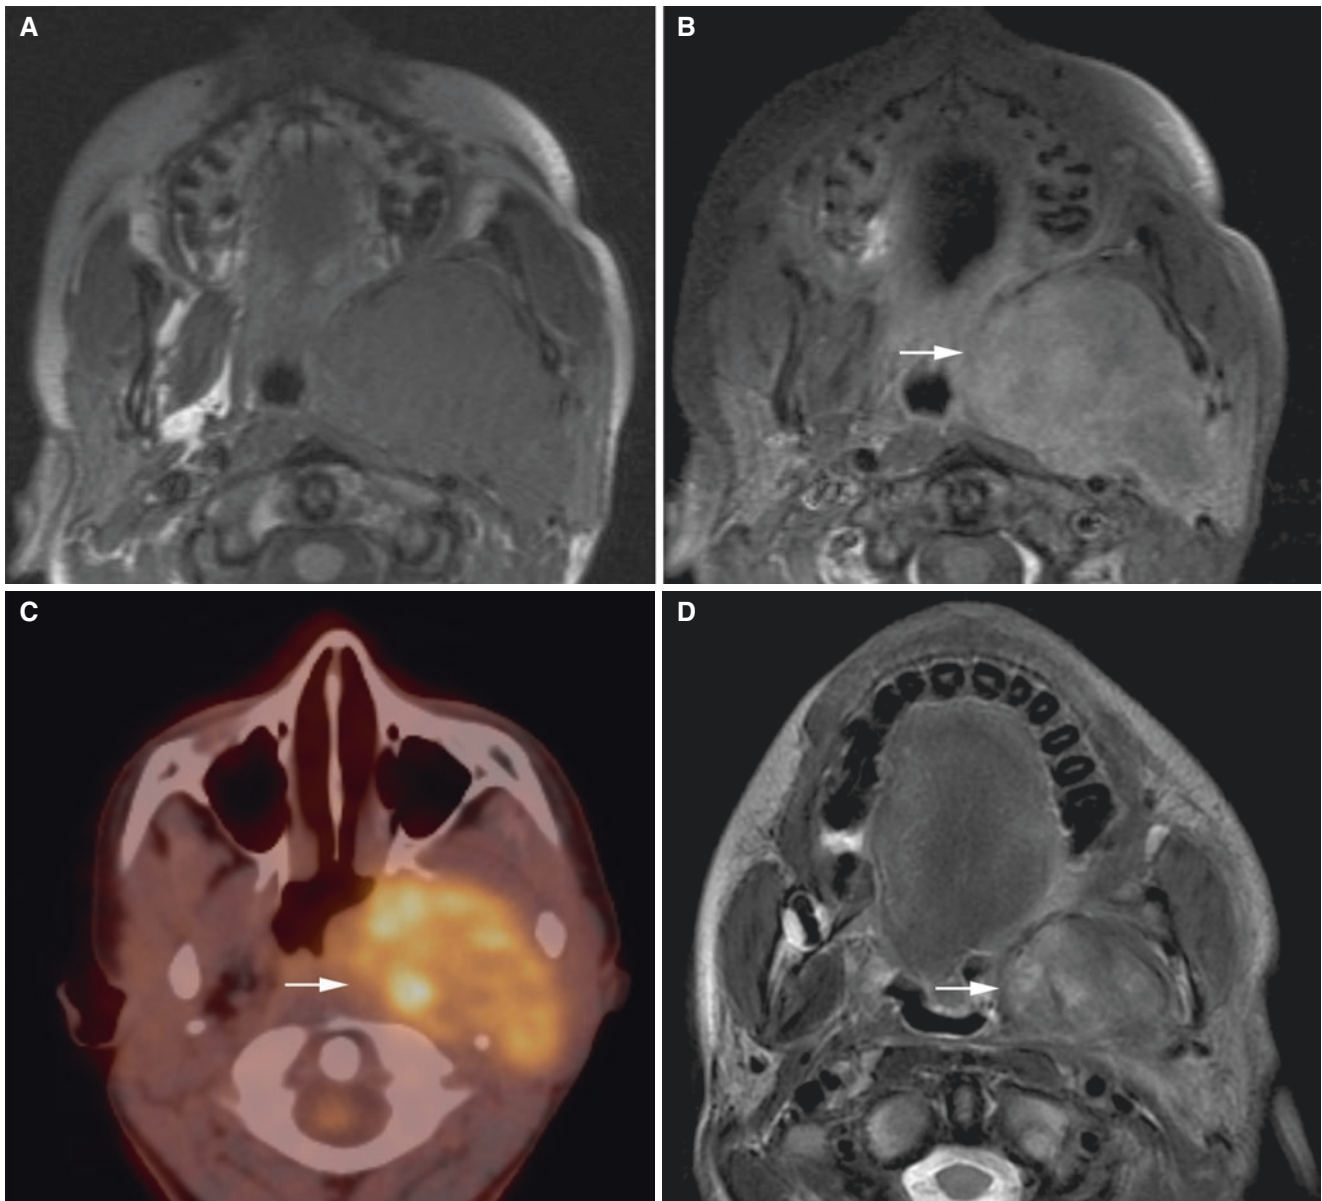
Rhabdomyosarcoma, parapharyngeal; 12-year-old male with trismus and a left-sided neck mass. (A) Axial T1-weighted pre-Gd and (B) axial T1-weighted fat sat post-Gd MRI show homogeneous contrast enhancement in tumor (*arrow*). (C) Axial PET-CT image
